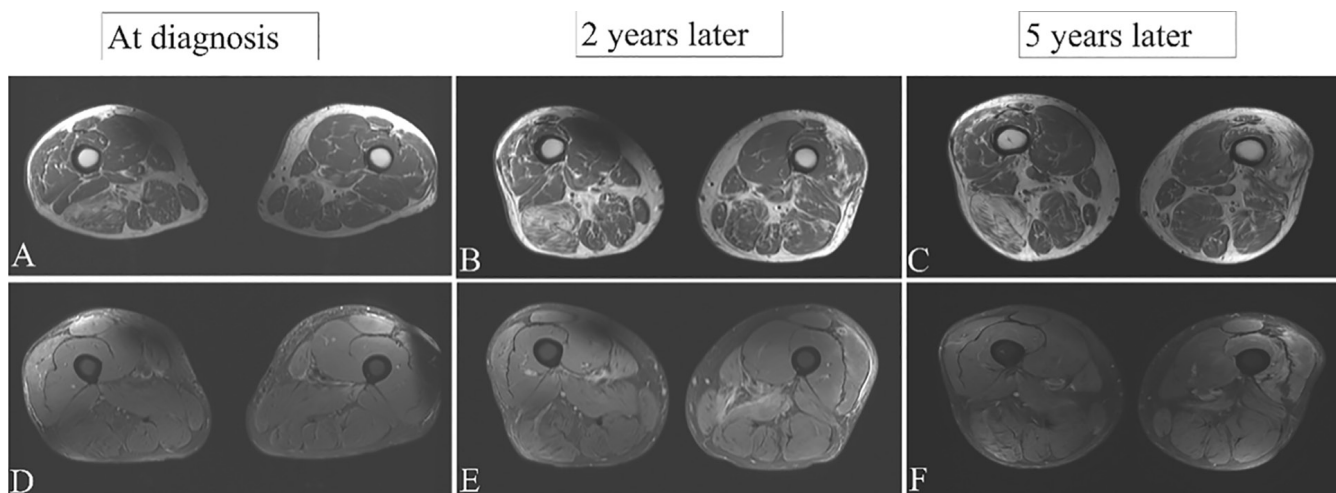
Muscle MRI from a patient with inclusion body myositis presenting with asymptomatic hyper-CKemia. Axial T1 (top row) and T2 (bottom row) sections from the thigh. At diagnosis, the patient had no demonstrable weakness of the knee extension on manual testing and was able to stand from kneeled position. He had mild fatty replacement of the right long head of the biceps femoris (A). 2 years later, he continued to have no weakness, and developed mild fatty replacement in the distal left vastus lateralis (B) with mild T2 hyperintensity (E). 5 years later, he developed mild to moderate weakness of the deep finger flexors and mild left quadriceps weakness. He became unable to stand from kneeled position on the left. MRI showed further progression of the fatty replacement in the distal quadriceps (C), most pronounced on the left side, with increased T2 hyperintensity (F) and relative sparing of rectus femoris.
